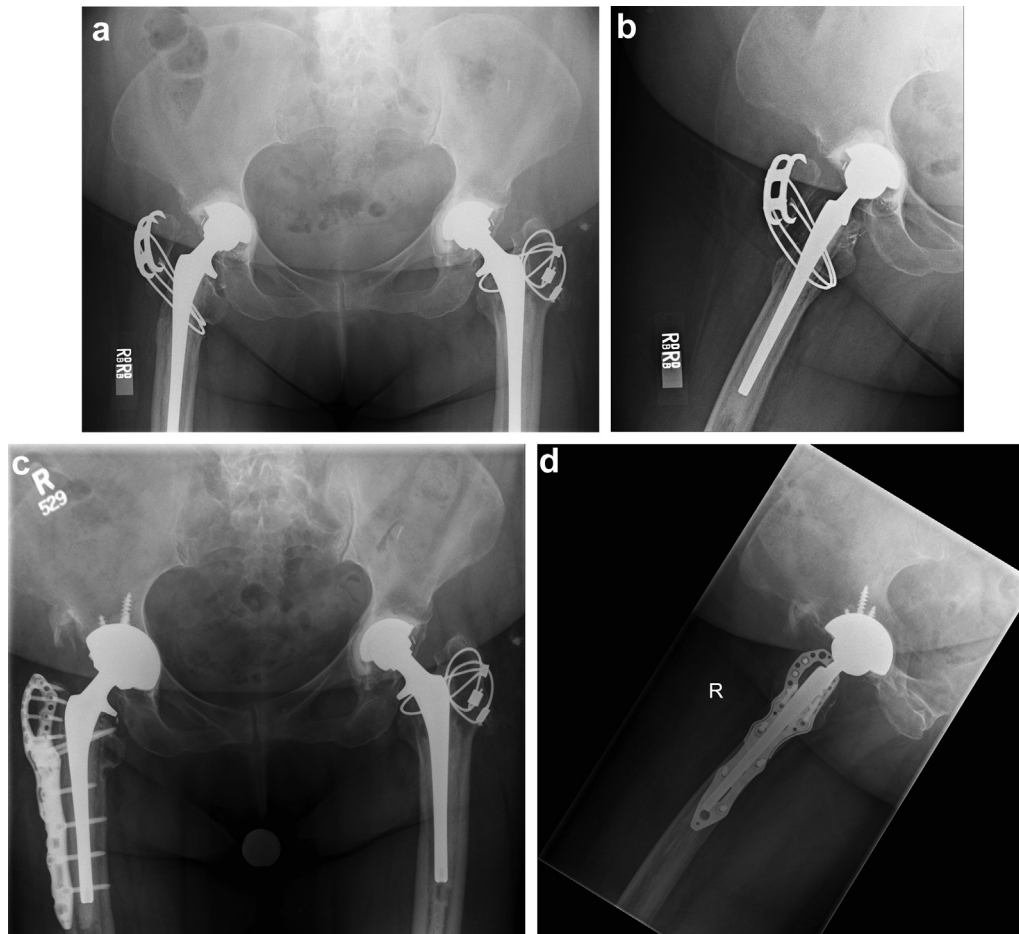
Anteroposterior pelvis (a) and lateral right hip (b) radiographs of patient with aseptic acetabular loosening of revision total hip replacement and concomitant painful trochanteric nonunion. The patient had significant Trendelenberg lurch and had failed prior attempts at trochanteric fixation. Anteroposterior pelvis (c) and lateral right hip (d) radiographs of patient arthroplasty revision and trochanteric fixation with a Zimmer NCB (Zimmer, Inc., Warsaw, IN) periprosthetic trochanteric plate and short femur plate assembly at 27 months. The patient had no limp and Harris hip score [14] of 94.
